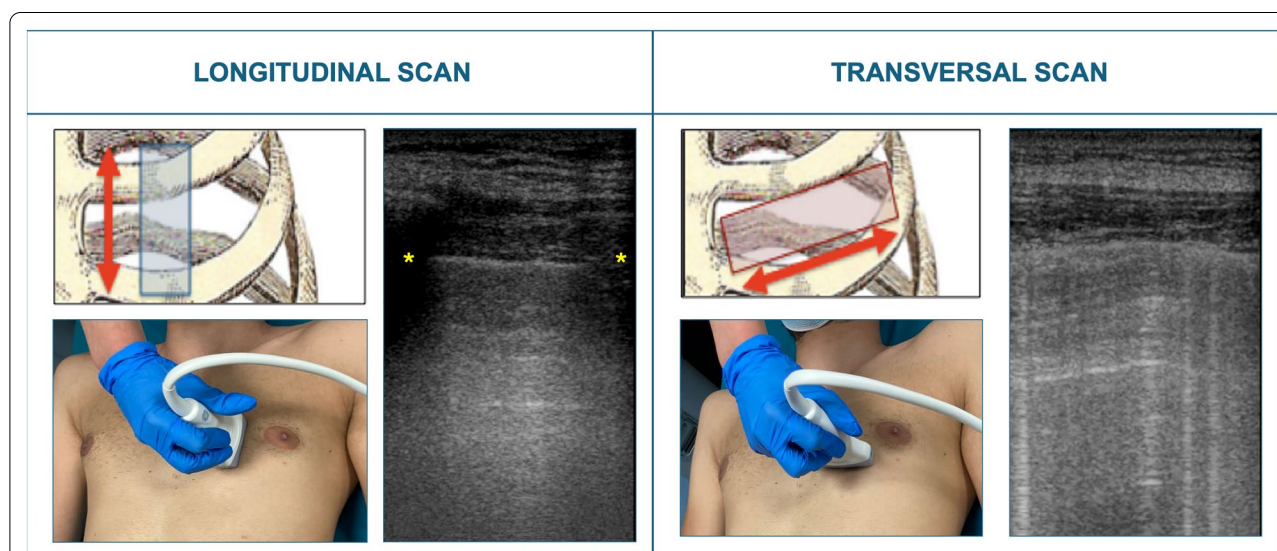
Different approaches for lung scanning. In the longitudinal scan the probe is aligned to patient's cranio-caudal axis; this approach allows clear identification of the pleural line in the intercostal space by the visualization of the bat sign; however, the width of visualized pleura is limited by the ribs' shadow (*). In the transversal scan, the probe is perfectly aligned with the intercostal space: a wider pleura is explored, improving the performance of lung ultrasound in the computation of the lung ultrasound aeration score. Ribs are more horizontal in neonates and infants and the probe orientation shall be adjusted accordingly. The transversal scan has advantages in adults, children and neonates, once the pleural line is correctly identified
